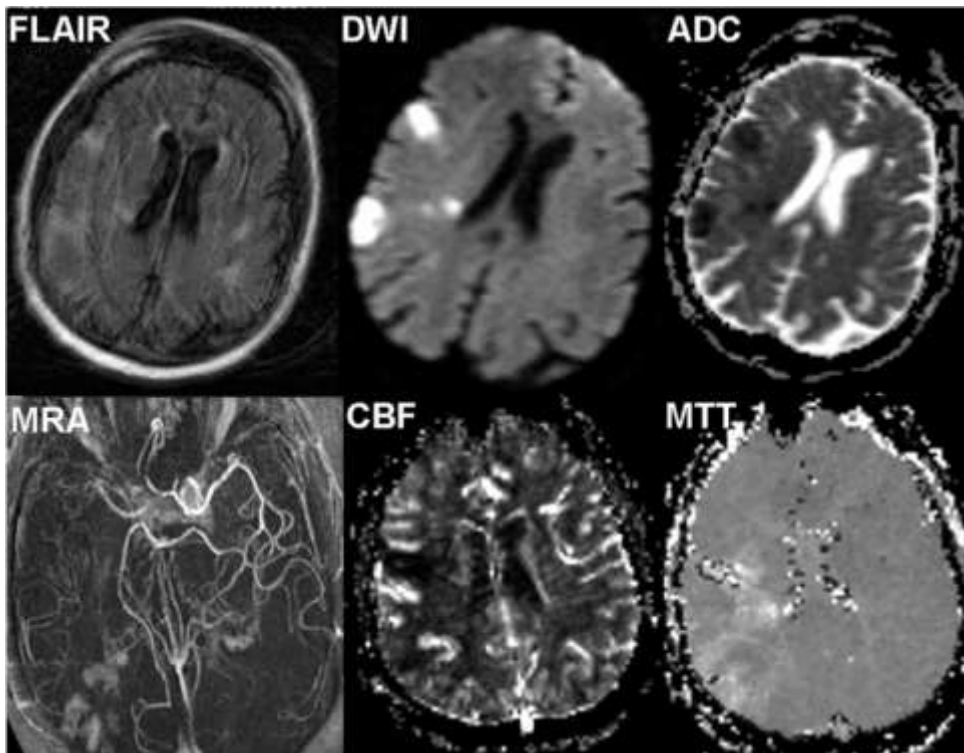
MR evaluation of acute stroke. In conventional FLAIR image there are multiple areas of signal hyperintensity involving the cortical ribbon in the right frontal lobe, characterized by signal hyperintensity in DWI and reduced water diffusion in ADC map. These areas of cytotoxic oedema are considered to correspond to the irreversibly damaged tissue (infarct core) caused by the occlusion of the right middle cerebral artery visible at MRA. MR perfusion obtained with DSC techniques allows calculating CBF and MTT maps that reveal a large area of hypoperfusion extending beyond the infarct core. The mismatch between DWI and PWI areas is the ischaemic penumbra.
